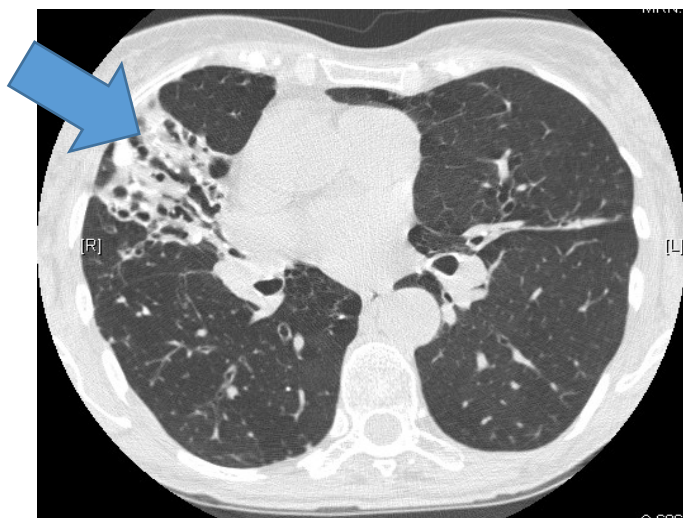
Computed tomography (CT) scan of patient with chronic *M. avium* complex disease in the right middle lobe in which bronchiectasis and inflammatory infiltrate are evident (arrow)
